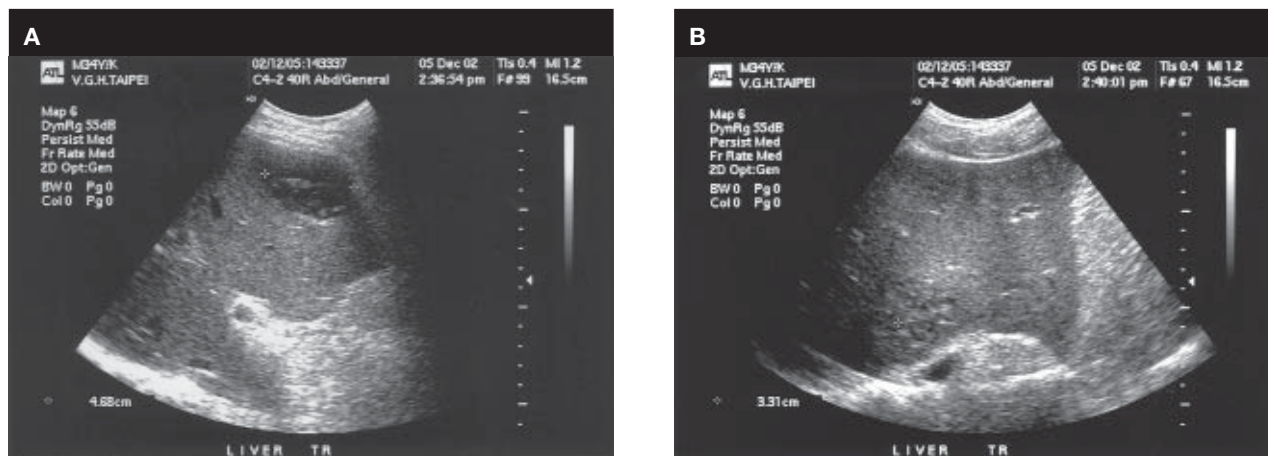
Abdominal sonogram shows complex intrahepatic lesions in the anterior (A, asterisk) and posterior portions of the liver (B, asterisk).
